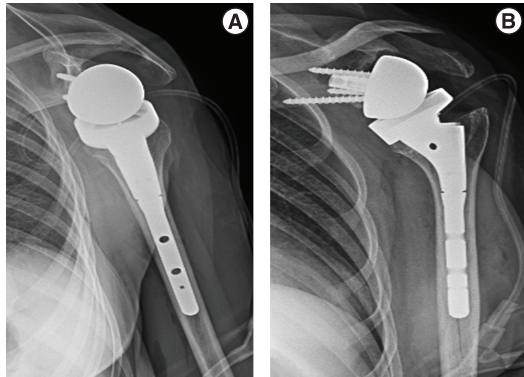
Shoulder radiographs immediately after surgery. (A) Lateral radiograph. (B) Anteroposterior radiograph.
